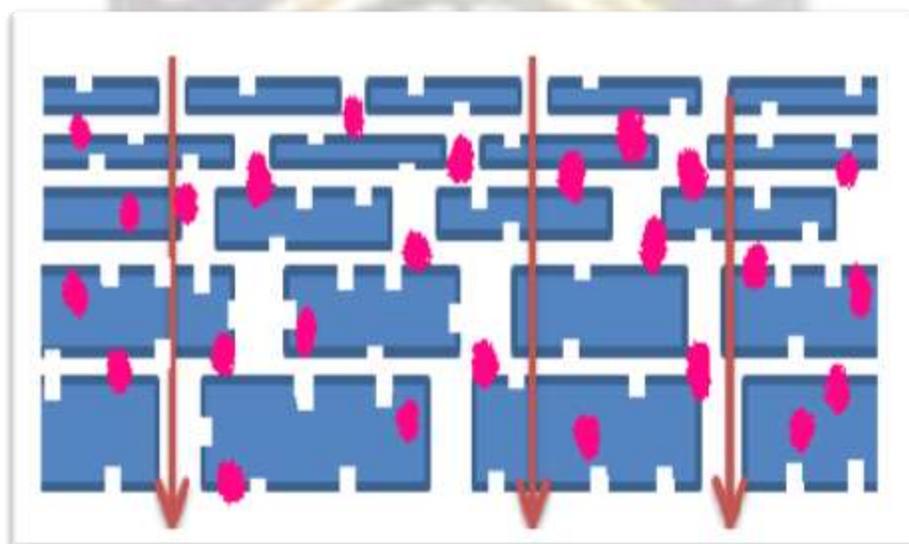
Enhanced permeation by disruption of lipid barrier and cavitation by use of ultrasound
